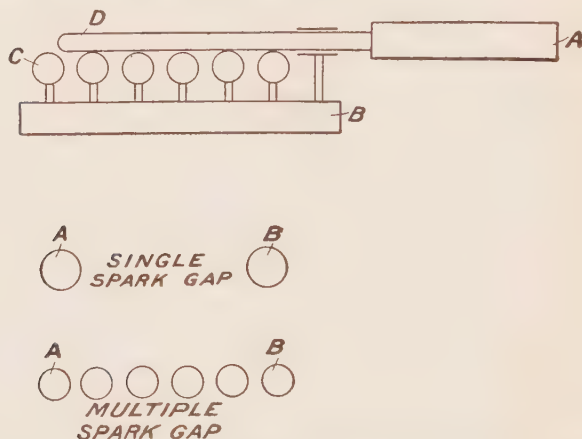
Represents a series multiple spark gap for use in circuit with an X-ray tube. The advantage of the multiple spark gap over the single is that a spark will be very much more steady when passed through a series of metal balls than when one single gap is used.
